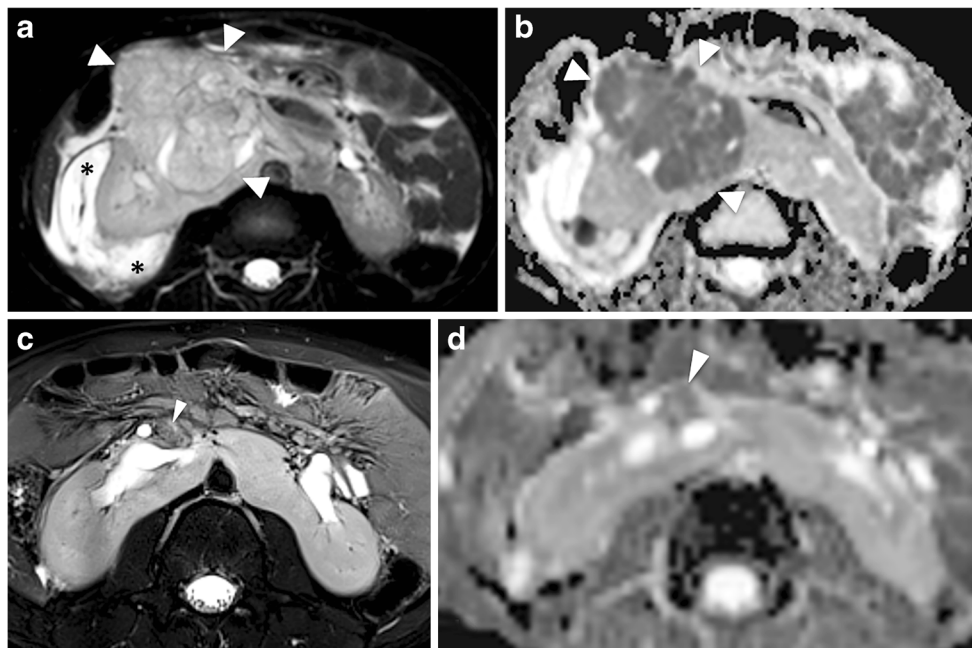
An 8-year-old boy with horseshoe kidney with a Wilms tumor. High-resolution T2-weighted image (a) with fat saturation shows a lobular heterogeneously hyperintense mass (*arrowheads*) centered within the lower pole of the right renal moiety extending across the midline toward the isthmus. There is associated complex right perinephric fluid collection (*asterisks*) suggestive of perinephric urinoma. The mass (*arrowheads*) demonstrates restricted diffusion on
